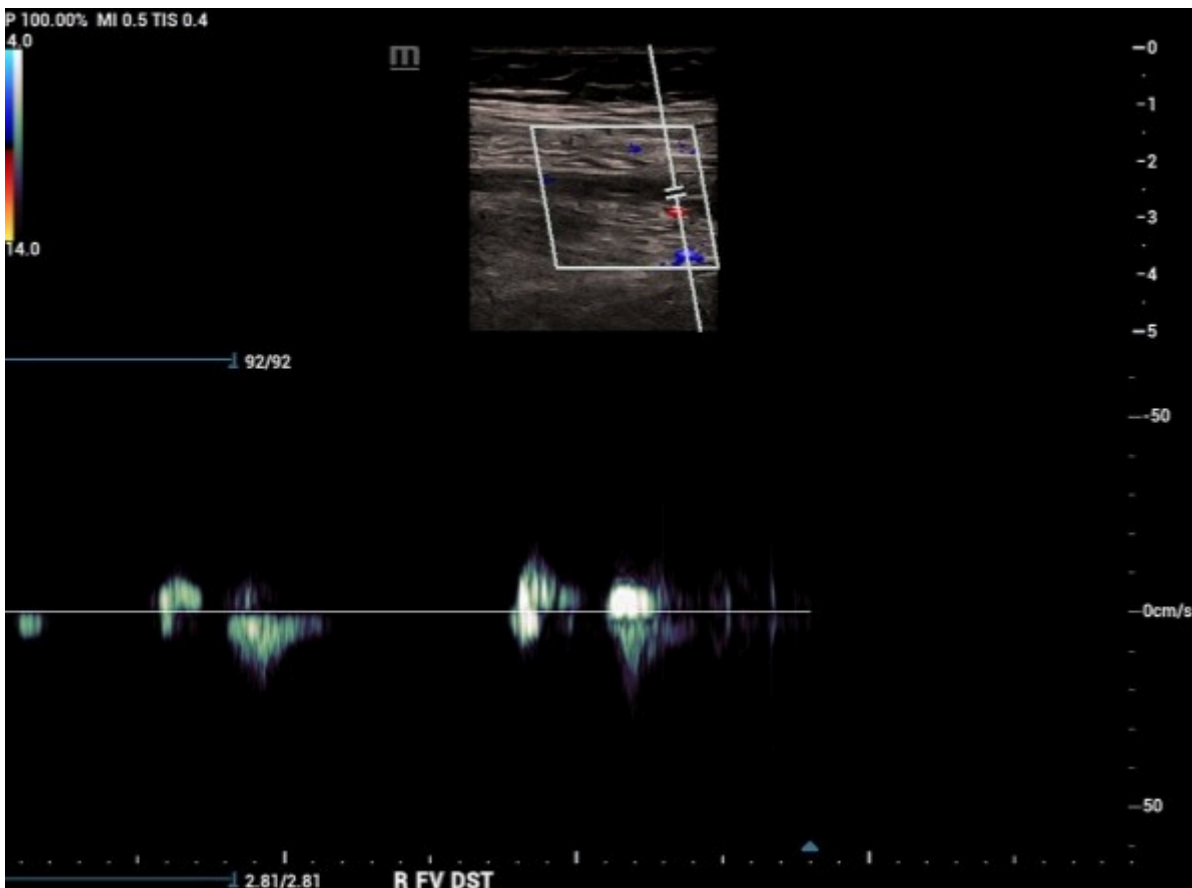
Long axis color doppler image of the distal femoral vein (FV) that is relatively small with peripheral filling defect and augmentation.
